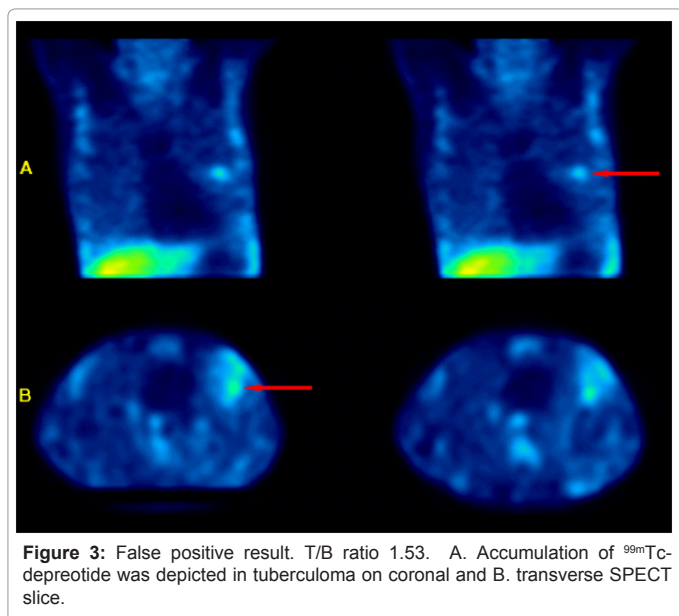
False positive result. T/B ratio 1.53. A. Accumulation of ^{99m}Tc-depreotide was depicted in tuberculoma on coronal and B. transverse SPECT slice.
